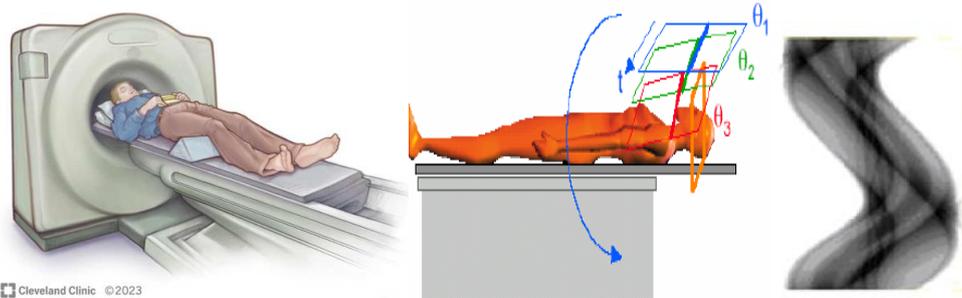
CT scan principle and organizing data into a sinogram
